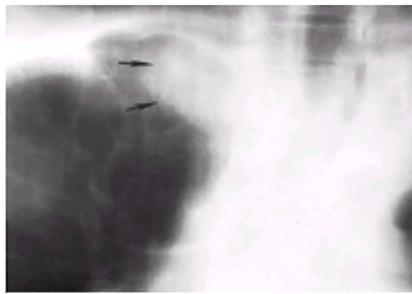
Radiation carcinogenesis? The patient presented in 1968 with Hodgkin's disease of the right supraclavicular region, for which he received mantle irradiation with x-rays. Details of the treatments are not available, but the field probably resembled that shown in Fig. 8. He returned 8 years later with a lesion in the paramediastinal region of the right upper lobe, shown in this tomogram (arrows). The lesion was resected and found to be a primary lung carcinoma within the fibrotic region of previous irradiation. A few months later the patient was also found to have a malignant thymoma, again within the field of previous irradiation.
